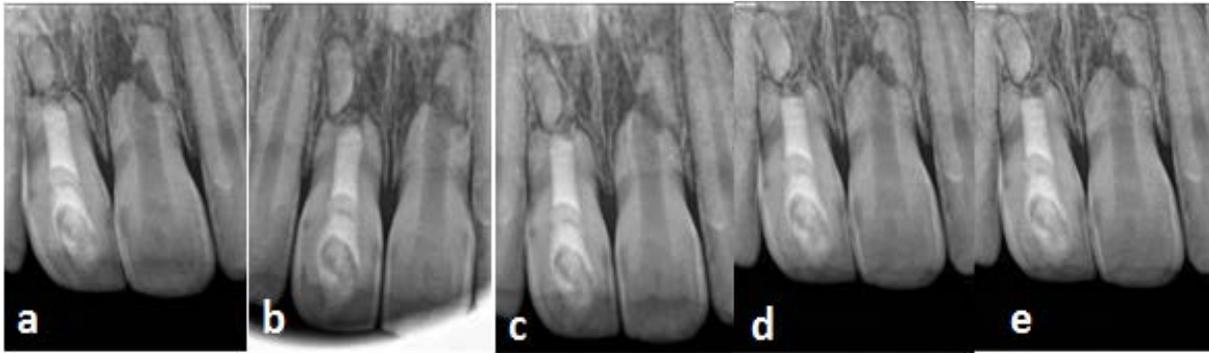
Follow-up radiographs are shown in figures A to E for 6, 12, 18, 24 and 36 months, respectively, on which we can see complete bone healing, ceasing of the resorbing of the apical part of the coronal segment of tooth #8, and lack of degenerative changes in periapical bone and the structure of tooth #9
